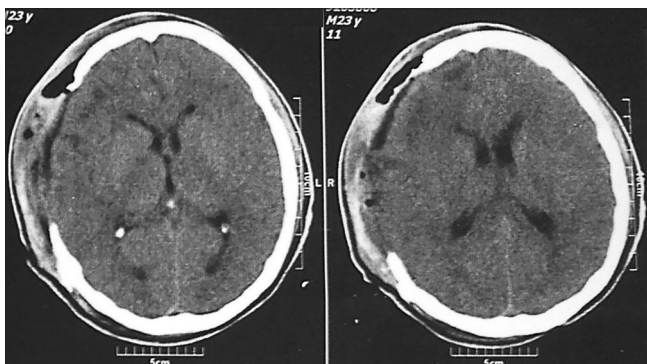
Postoperative computed tomography scan shows reduction of mass effect without additional bleeding
